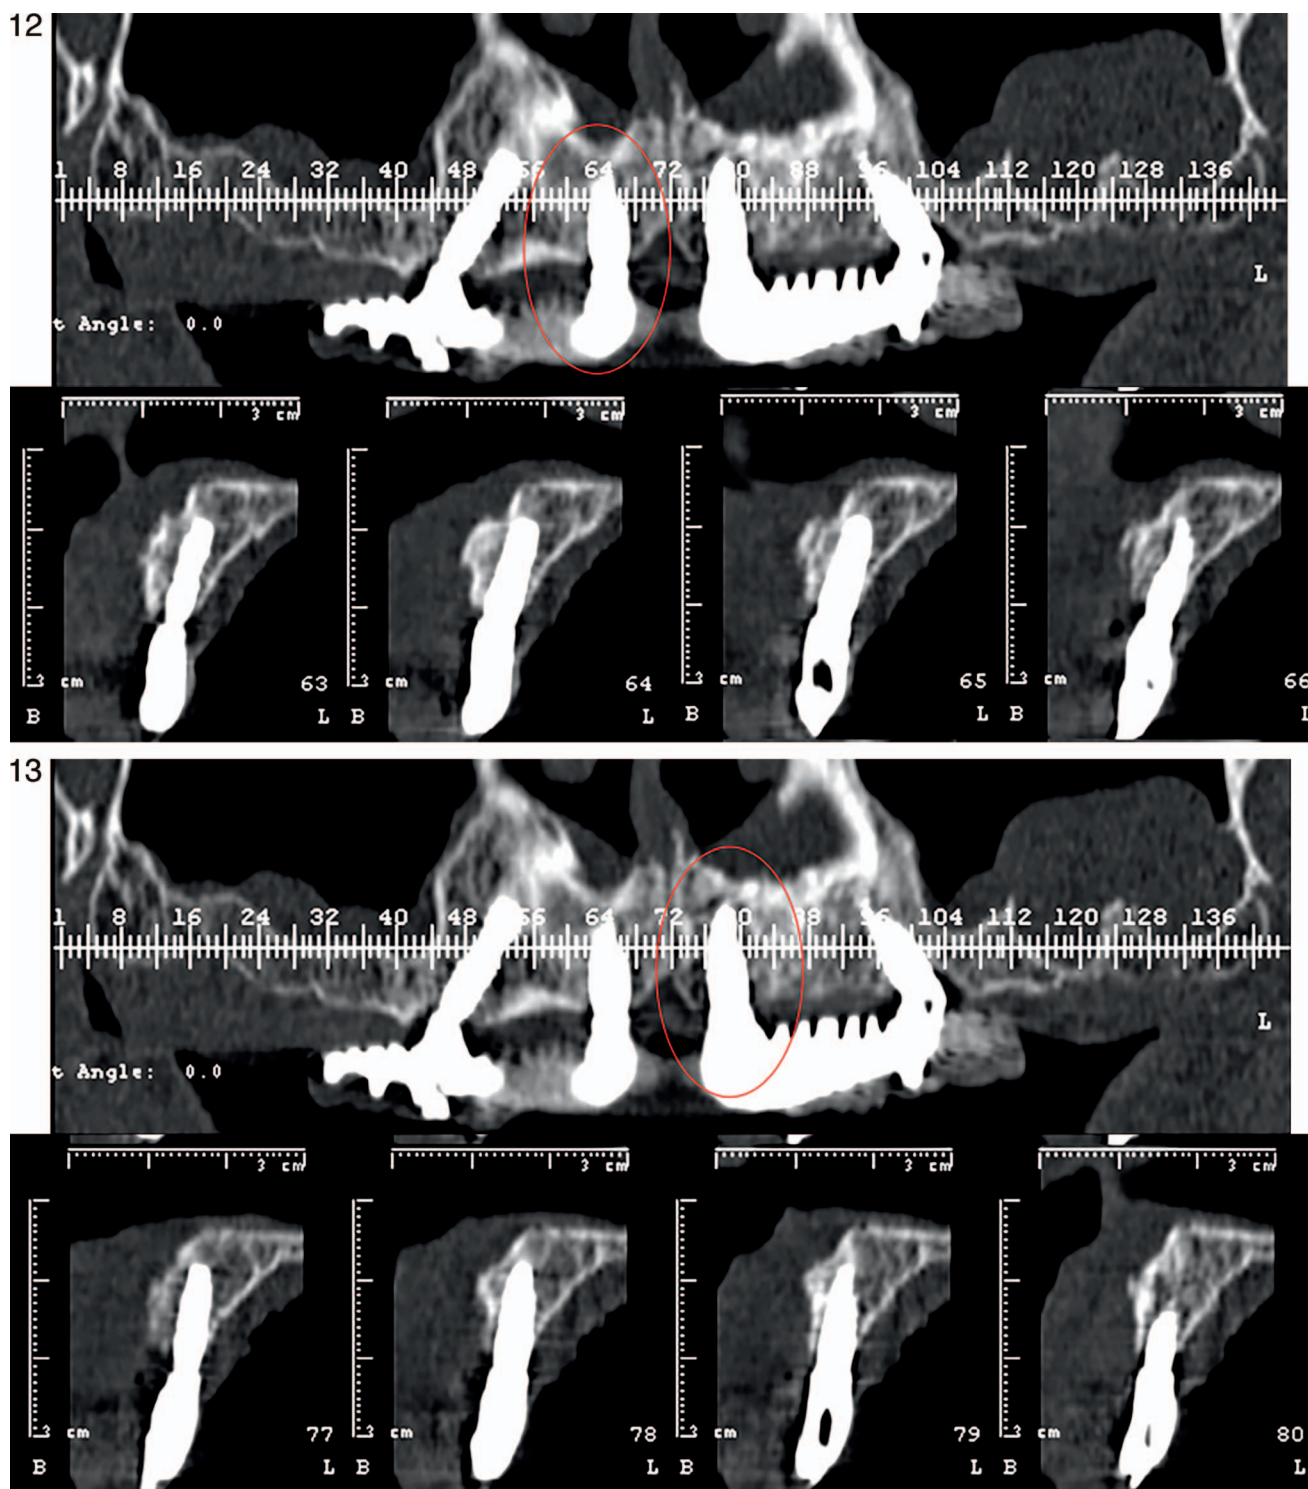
Orthopantomography after prosthetic loading.
